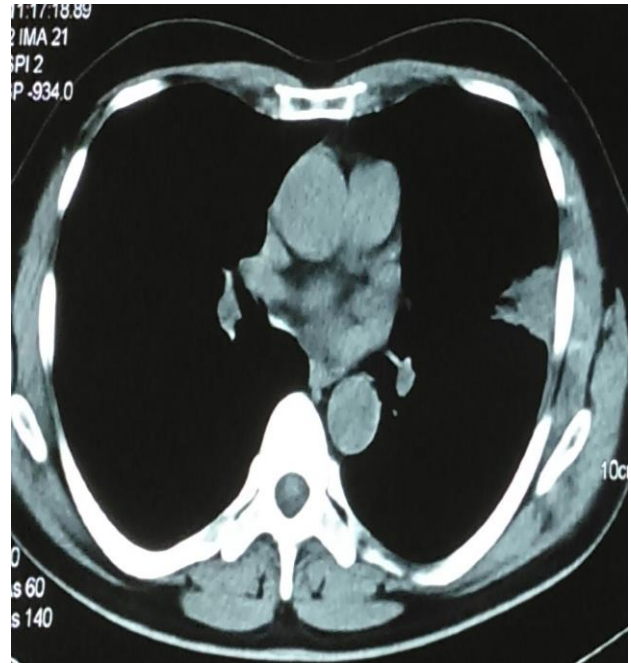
CT image suggesting wedge-shaped opacity in the left lower lobe.
